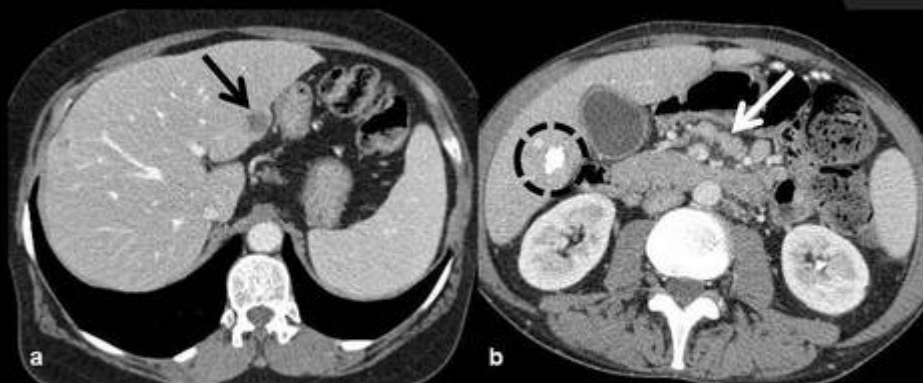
a - Woman, 30 years old, immunocompromised, with fever and weight loss. Abdominal CT after iv contrast discloses a few hepatic hypodense nodules, one of them with central necrosis (black arrow). B - Man, 43 years old, with history of hepatic tuberculosis and actually with lymph node tuberculosis. Abdominal CT after iv contrast shows a coarse calcified granuloma in the liver (circle) and a lot of homogeneous mesenteric lymphadenopathy (white arrow).
